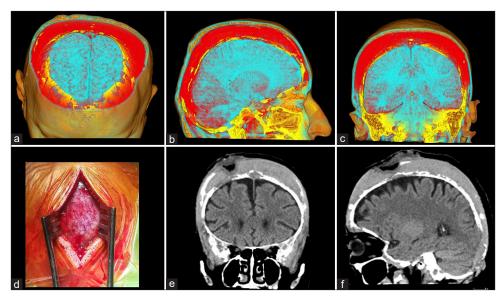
Neurosurgical procedure. (a-c) Axial, coronal, and sagittal slice reconstruction using OsiriX MD program showing the "helmet" CVL (red color); (d) intraoperative appearance of the tumor; and (e and f) non-contrast head computed tomography scan, coronal, and sagittal slice, respectively, showing the site of the operation at the level of the right Kocher's point.
